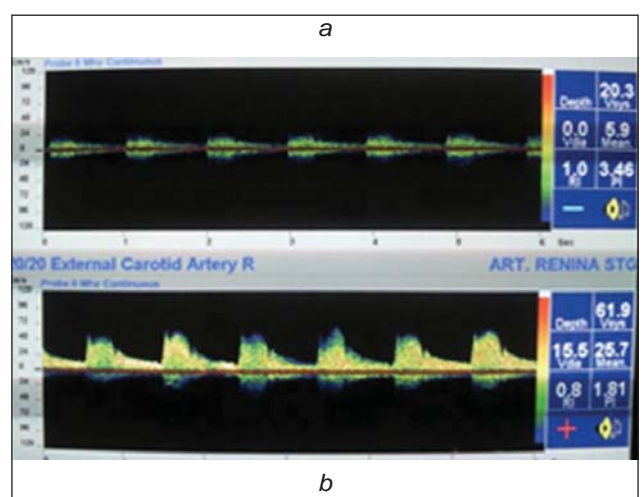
Patient TL-Spectral analysis cw-Extracranial Doppler ultrasound of the left lingual artery. Peak flow velocity is 61.9 cm/s in the stenosis (A), and 20.3 cm/s behind the stenosis (B).
